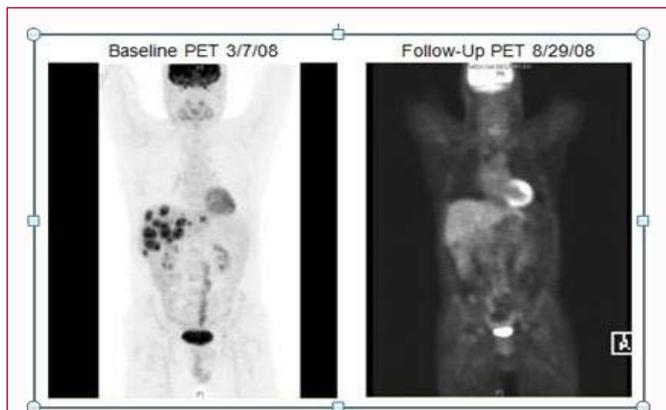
Case A. The baseline PET scan shows hyper-metabolic, hepatic metastases. The follow-up PET scan, after 6 months of liver-directed and systemic chemotherapy, reveals response to treatment with just one focus, in segment 4A, of residual, hepatic, hypermetabolic activity, with a CT correlate, suspicious for viable disease.
